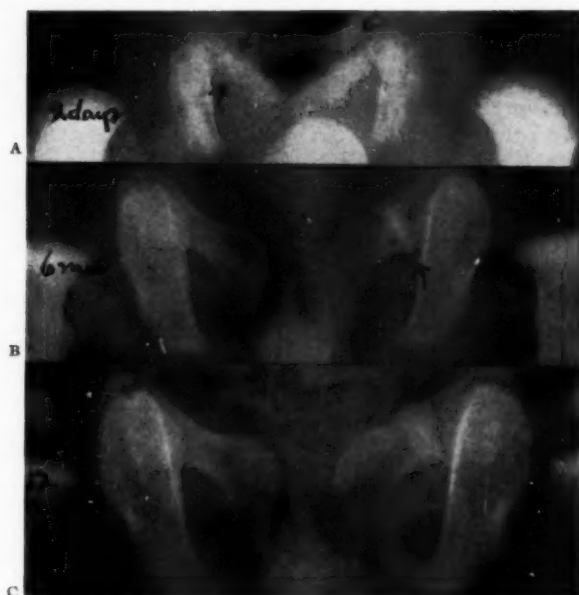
Radiographic appearance of double pubic ossification centers. A. Two days. B. Six months. C. Twelve months.
